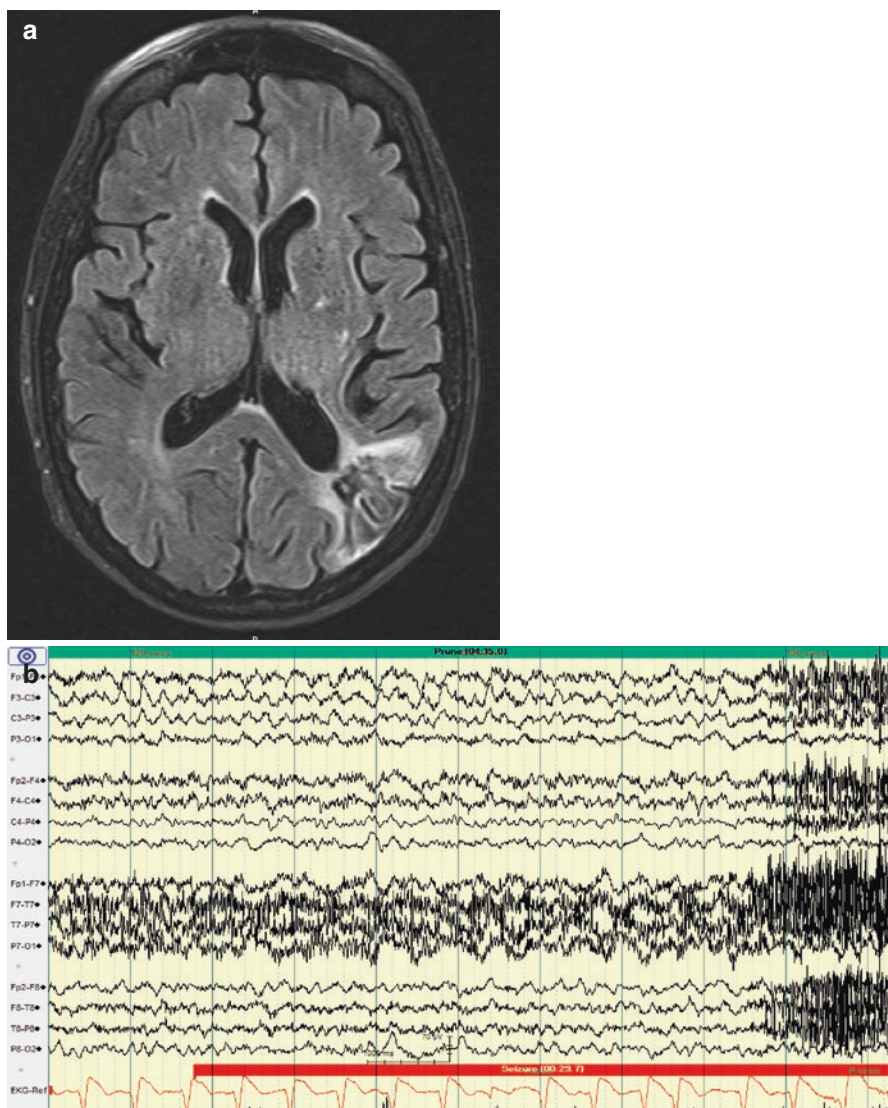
(a) Head CT of a 68-year-old female with previous history of ischemic right parietal infarct who was found down thought to be due to seizures. (b) The interictal EEG shows LPDs over the right hemisphere maximal over the frontotemporal electrodes
